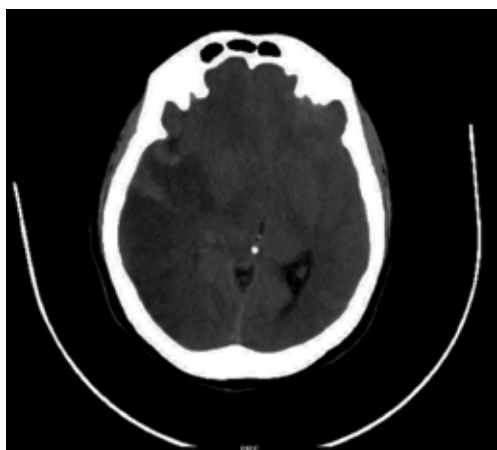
CT Brain showing an acute cerebral infarct with haemorrhagic transformation involving the right parietal, temporal and occipital lobes
